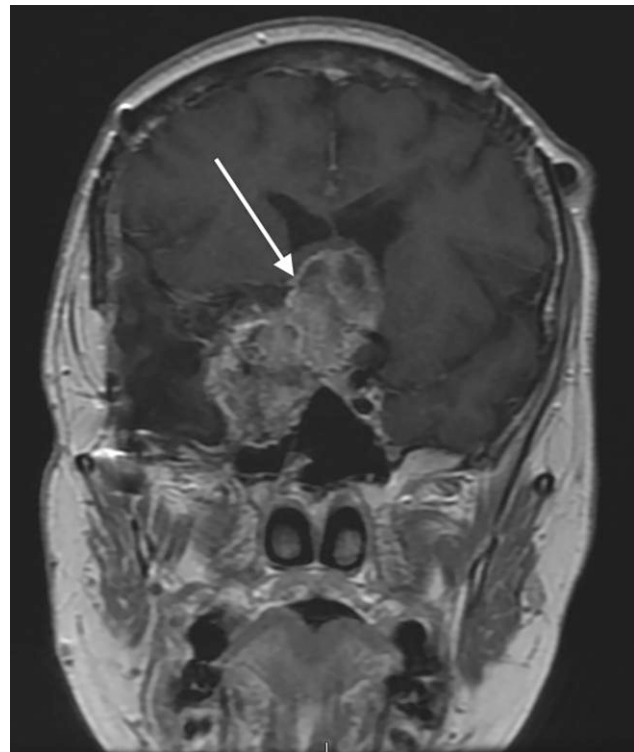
Gadolinium-enhanced magnetic resonance imaging of the brain (T1-weighted coronal view), performed 5 years after the imaging in Figs. 1 and 2, showing a calcified mass on the skull base that extends into the cavernous sinus and sella turcica and leads to mass effect onto the suprasellar area.
